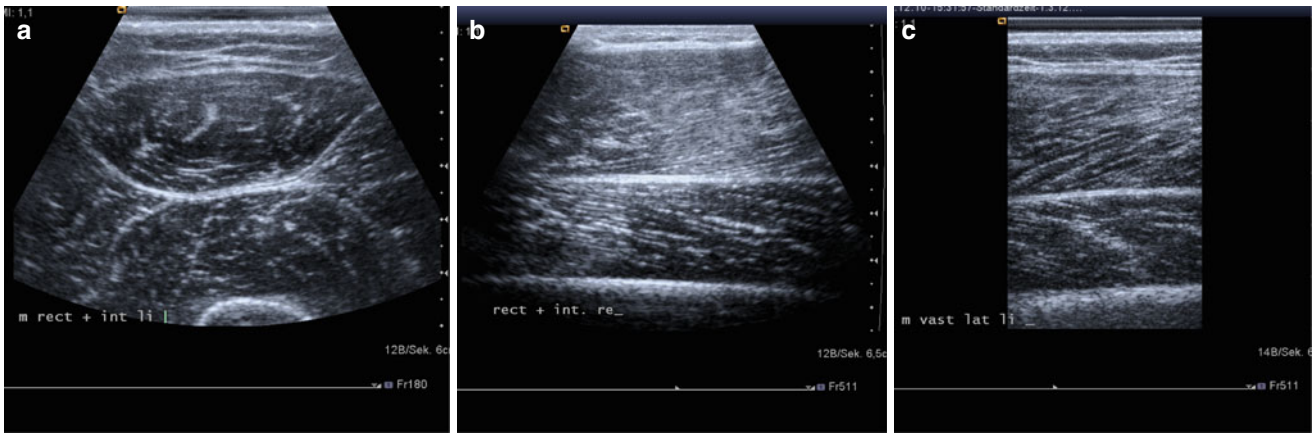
Ultrasound images of muscle are useful for the evaluation of muscle tissue and also in intervention, such as botulinum toxin. These images show a transverse (a) and longitudinal (b) section of the rectus
